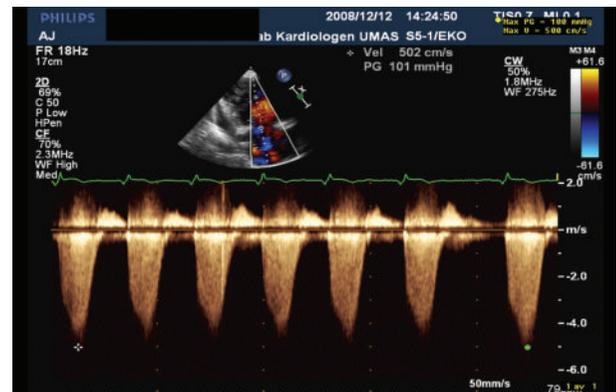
Estimation of the pulmonary arterial systolic pressure (PASP) from the tricuspid regurgitant jet (V_{TR}). The latter is measured using continuous wave Doppler. PASP is calculated from simplified Bernoulli equation, $PASP = 4 \times V_{TR}^2$.
